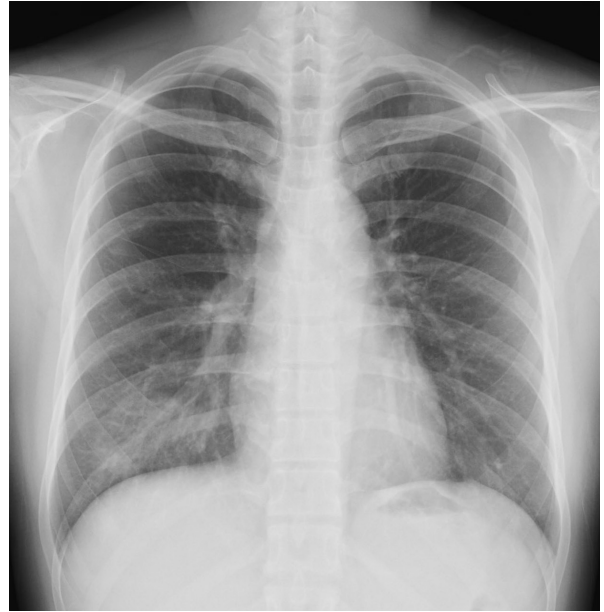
Chest X-ray showed an oval opacity with central lucency in the right lower lung.
